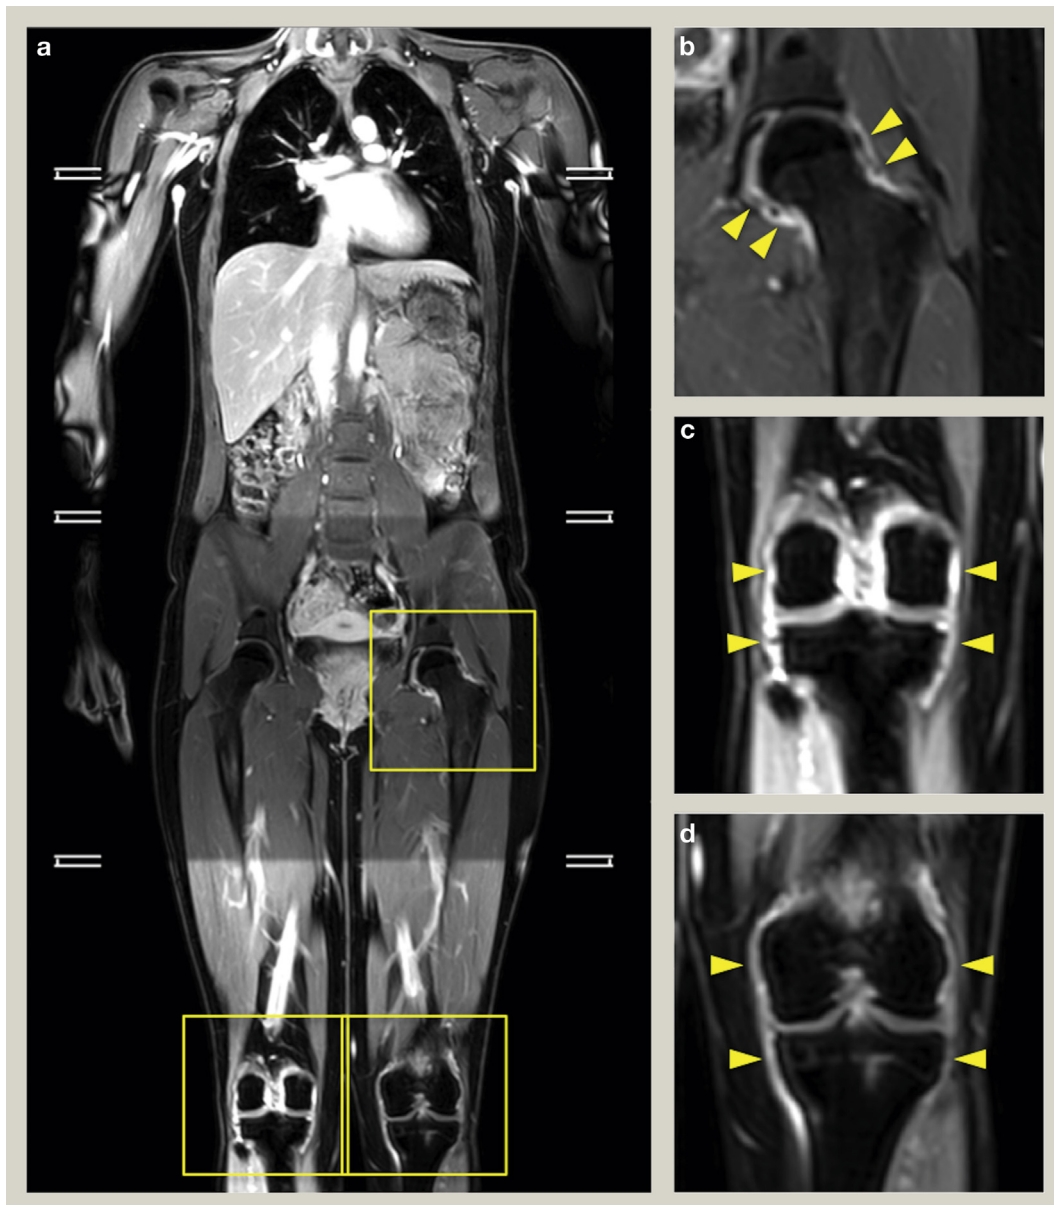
Whole-body MRI (WB-MRI) of a 22-year-old patient with polyarticular juvenile inflammatory arthritis. WB-MRI can image multiple joints, facilitating assessment of the distribution and severity of joint inflammation. (a) Large field of view image showing enhancing active synovitis in the left hip and right knee. Note the asymmetry of the hips, with lack of synovial enhancement of the right hip. Magnified views of the diseased left hip (b) and right knee (c) (compare with a normal left knee, seen in (d)), with arrowheads depicting the enhancing synovium.
